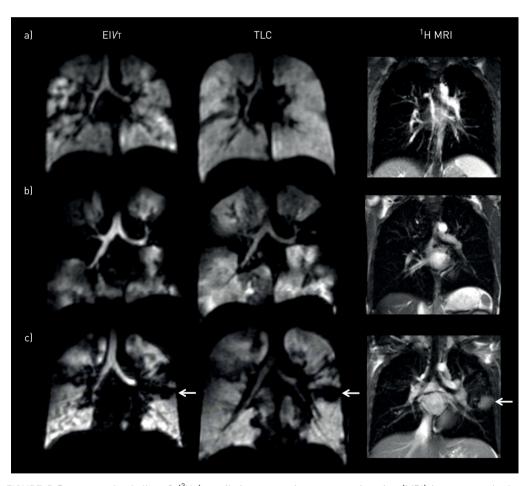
Representative helium-3 (³He) ventilation magnetic resonance imaging (MRI) images acquired at end-inspiratory tidal volume (EIVT) and total lung capacity (TLC) from three subjects, with representative ¹H MRI. a) Forced expiratory volume in 1 s (FEV1) z-score –0.5, lung clearance index (LCI) 7.7, residual volume (RV)/total lung capacity (TLC) 22.4%. This subject has ventilation defects present at EIVT (ventilation defect percentage (VDP) 5.4%), which largely disappear at TLC (VDP 0.4%), reversible-volume index 1.2; b) FEV1 z-score –3.7, LCI 17.8, RV/TLC 50.3%. This subject has ventilation defects present at EIVT (VDP 39.5%), some of which remain at TLC (VDP 18.2%), reversible-volume index 2.0; c) FEV1 z-score –1.1, LCI 7.4, RV/TLC 24.8%. This subject has ventilation defects present at EIVT (VDP 6.5%), which largely remain at TLC (VDP 5.3%) and therefore has a low reversible-volume index (1.0). The cause of part of the nonreversible ventilation can be seen in the left lung on the ¹H image where an area of significant mucus is present, corresponding to the ventilation defect seen on both EIVT and TLC ventilation images (arrow).
